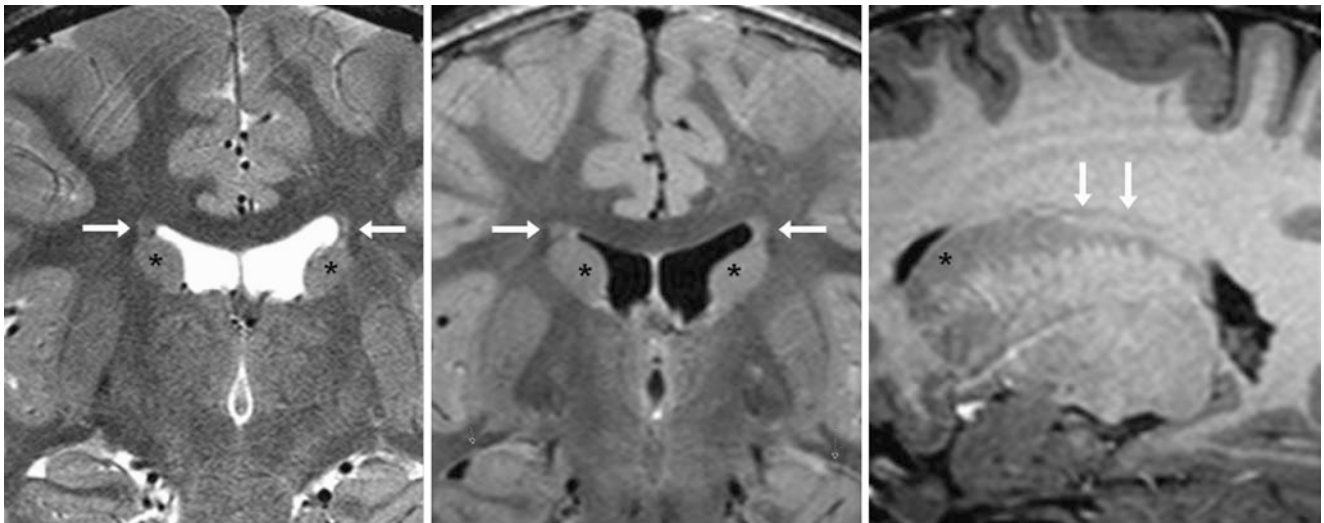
A 7 year old had a 3 T MRI performed for seizures (negative study). Bilateral PEPs (*arrows*) are noted immediately superior to the caudate nuclei (*) on coronal T2WI (*left*) and FLAIR (*middle*), but they are not well visualized on sagittal T1WI (*right*). Their signal intensity is similar to the caudate nuclei and may be mistaken for nodular heterotopia
